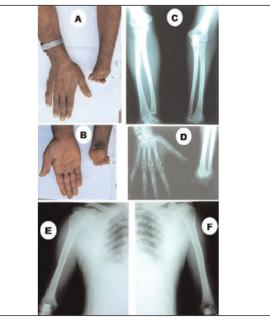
Limb phenotype in the subject. A-F: Photographs and radiograph of upper limbs.
